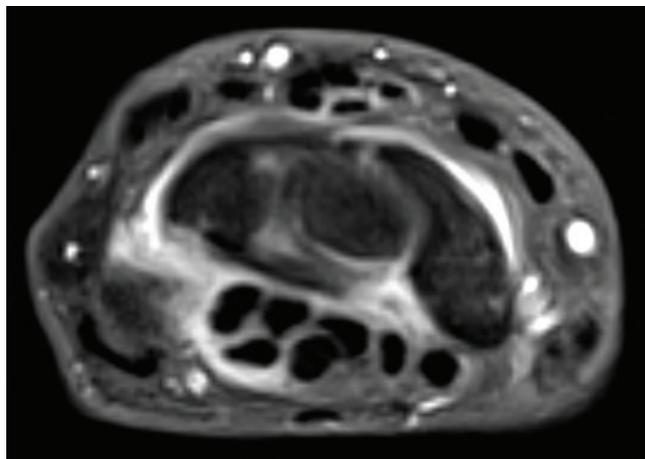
MRI, T1 TSE FS CM, axial plane: midcarpal joint synovitis, tenosynovitis of the flexors and 4th compartment of extensor tendons
